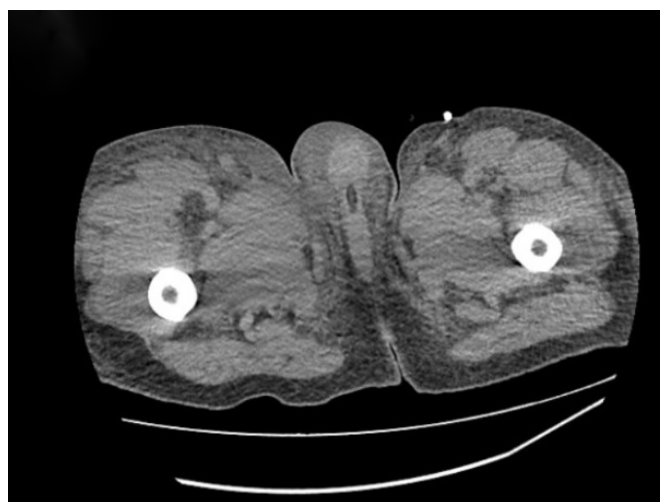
Computed tomography of the lower limbs on the 4th day of hospitalization showing diffuse skin and subcutaneous edema without loss of continuity.
